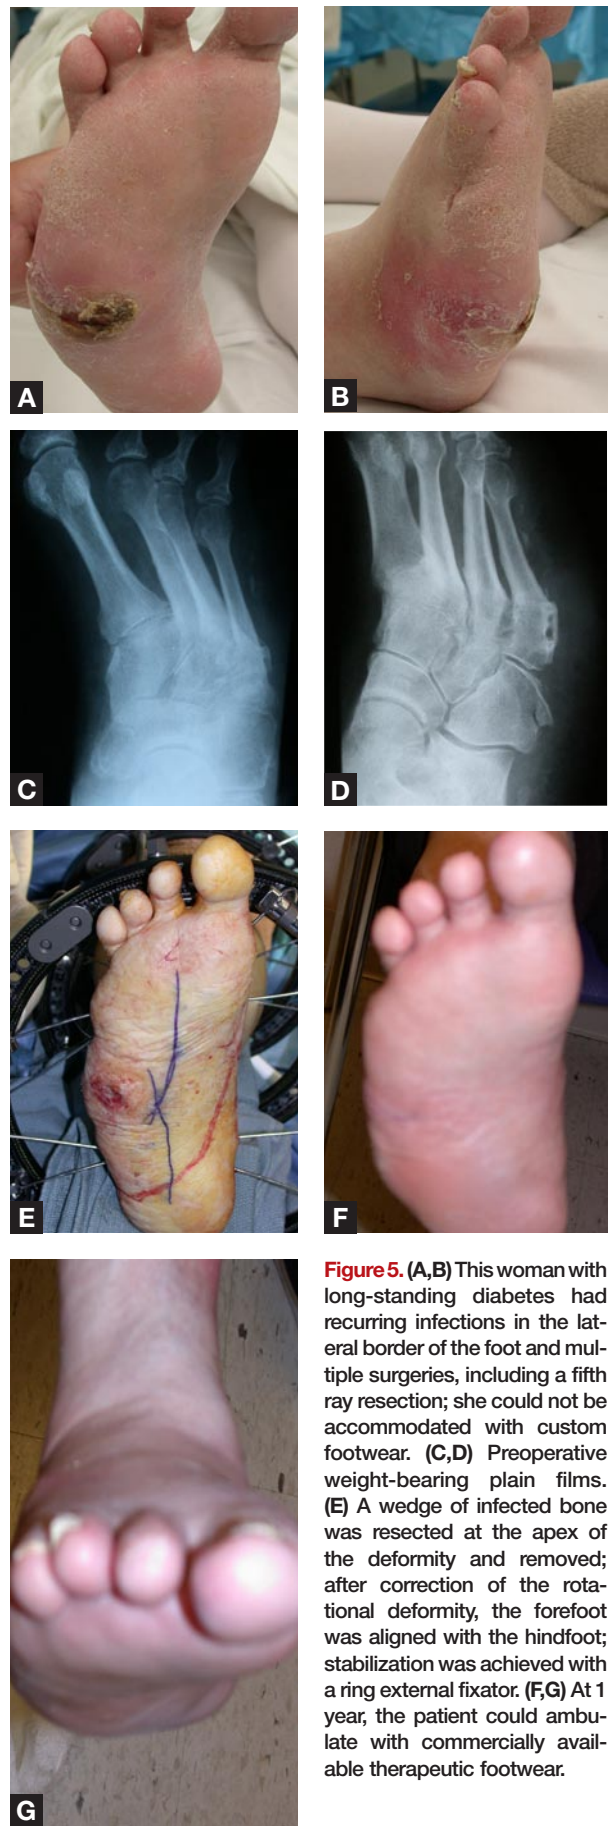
(A,B) This woman with long-standing diabetes had recurring infections in the lateral border of the foot and multiple surgeries, including a fifth ray resection; she could not be accommodated with custom footwear. (C,D) Preoperative weight-bearing plain films. (E) A wedge of infected bone was resected at the apex of the deformity and removed; after correction of the rotational deformity, the forefoot was aligned with the hindfoot; stabilization was achieved with a ring external fixator. (F,G) At 1 year, the patient could ambulate with commercially available therapeutic footwear.
